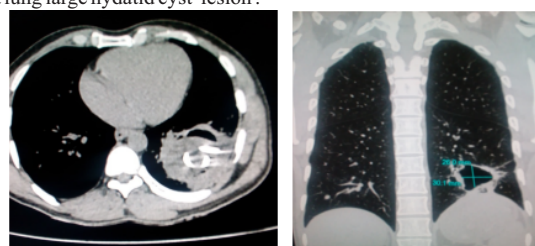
Non contrast computed tomography image of chest show percutaneous drainage. catheter in situ in left lung hydatid cyst lesion.
